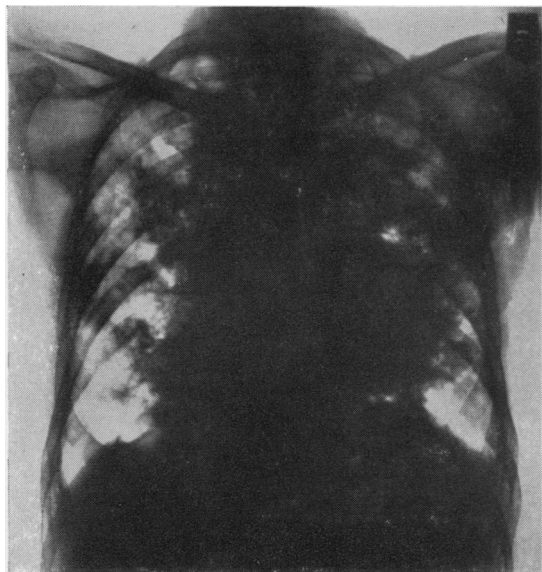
Chest radiograph showing patchy mottling in the right upper zone, dense mottling in the right mid zone, and less extensive similar patchy mottling in the left upper and mid zones. Basal areas appear emphysematous.
